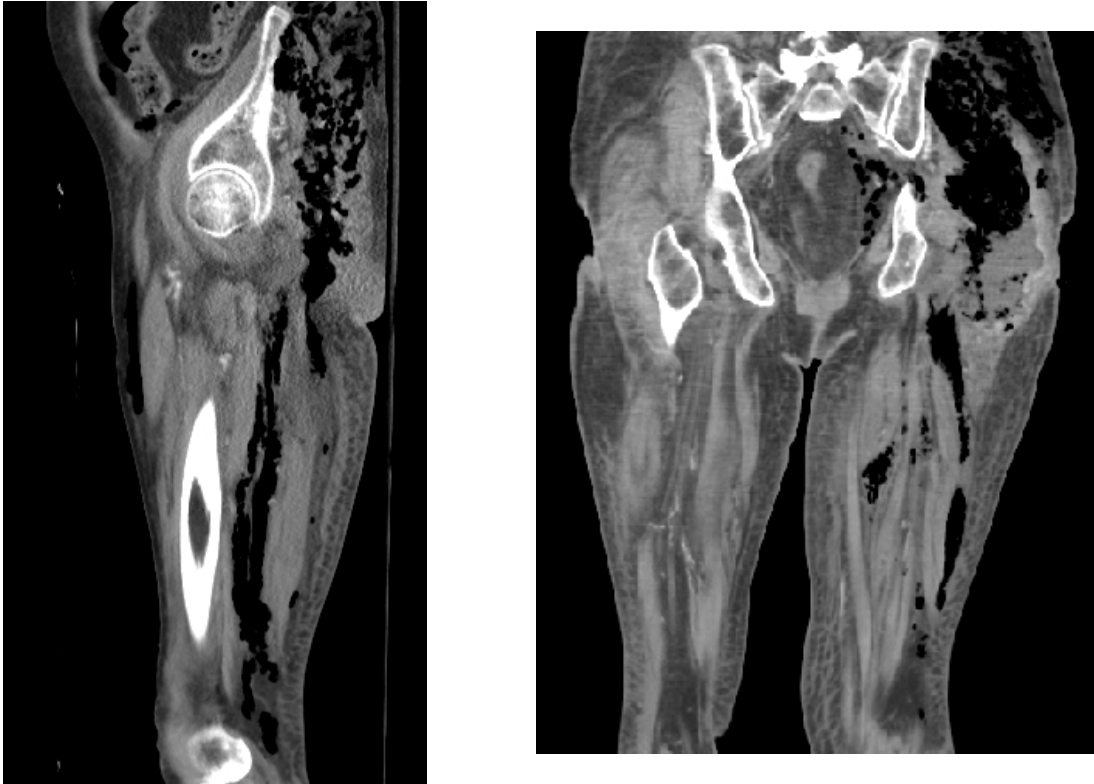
CT Image showing impressive amount of gas extending up the fascial planes in the upper left leg and gluteal area.
